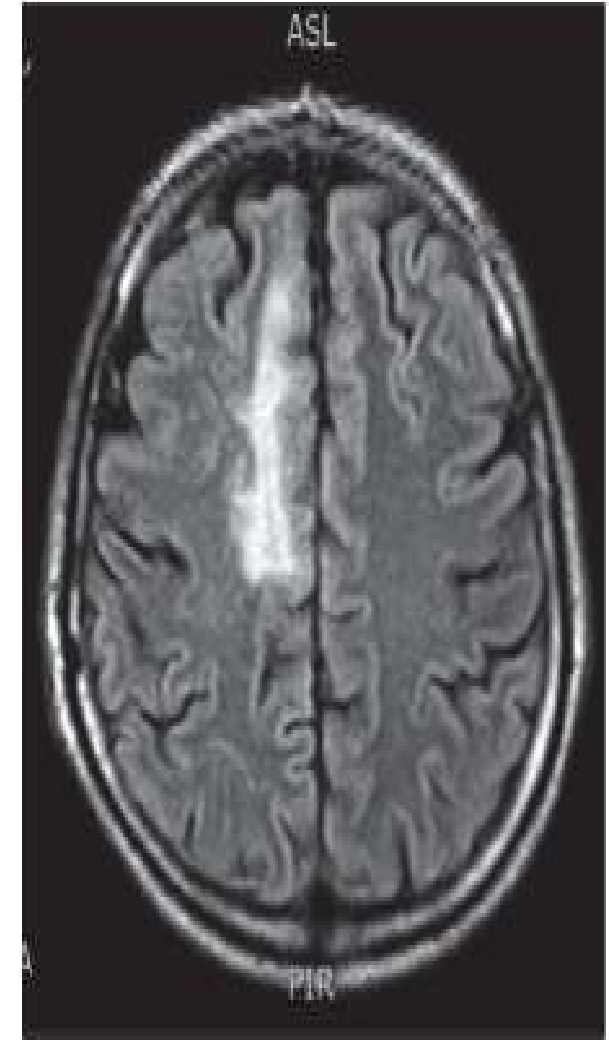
A magnetic resonance image showed a hyperintensity in T2 on the upper and lower right frontal gyri, in the left occipital lobe, and lesions with annular enhancement in the deep upper left temporal sulcus (case report 1).
